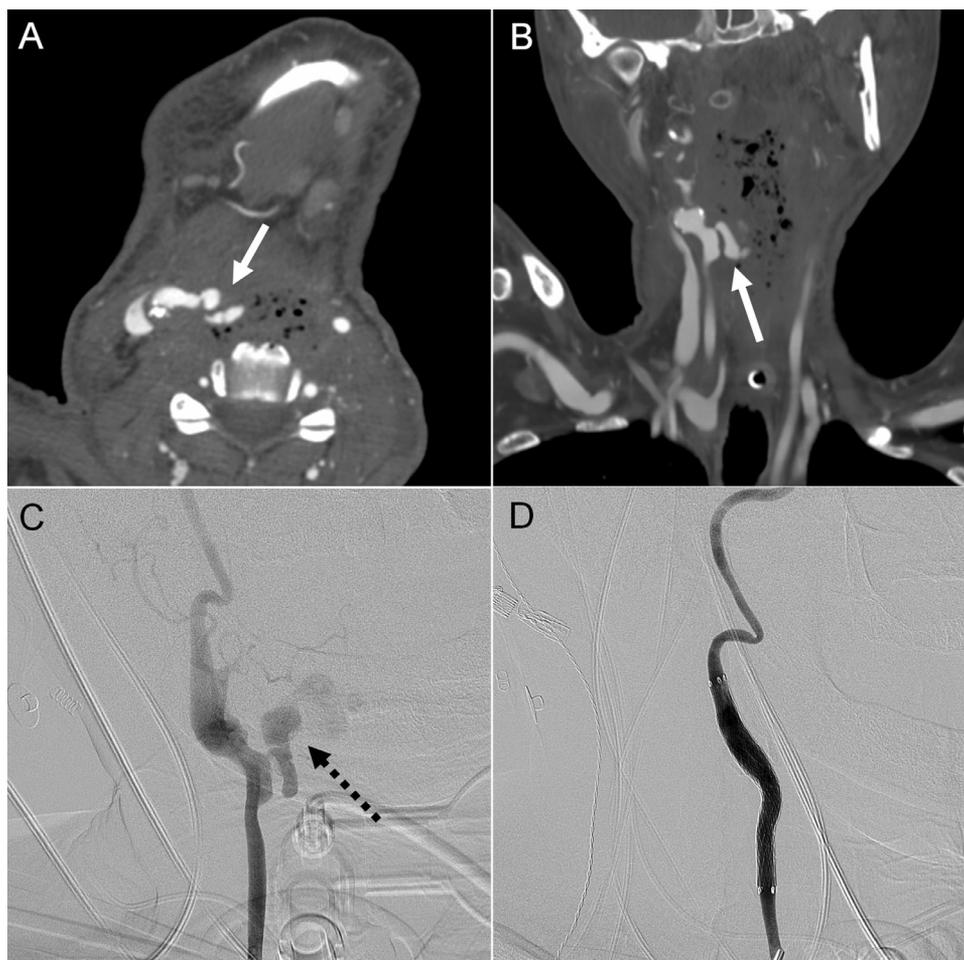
A 57-year-old with a history of a remote laryngeal cancer, total laryngectomy, and radiation who presents with brisk hemoptysis. A CT angiogram in the axial (A) and coronal planes (B) show a multilobulated focal outpouching consistent with a carotid pseudoaneurysm arising from the medial edge of the right common carotid artery and communicates with the airway (A-B white arrows) consistent with a carotid blow out. The patient was taken for emergent catheter based angiography (C) which confirms the multilobulated pseudoaneurysm (C, dashed arrow) suspected on CTA. The patient was successfully treated with an endovascular stent placed over the pseudoaneurysm (D).
